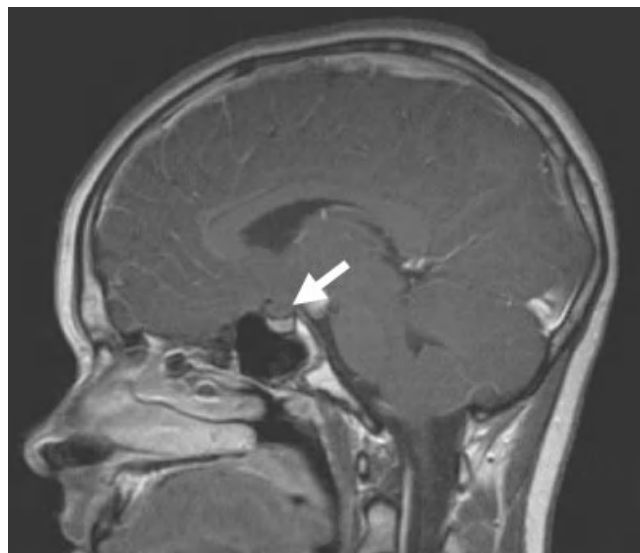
Sagittal magnetic resonance image from an 8-year-old boy with clinical features of gonadotrophin-dependent precocious puberty showing a hypothalamic mass with the growth characteristics of a glioma.
